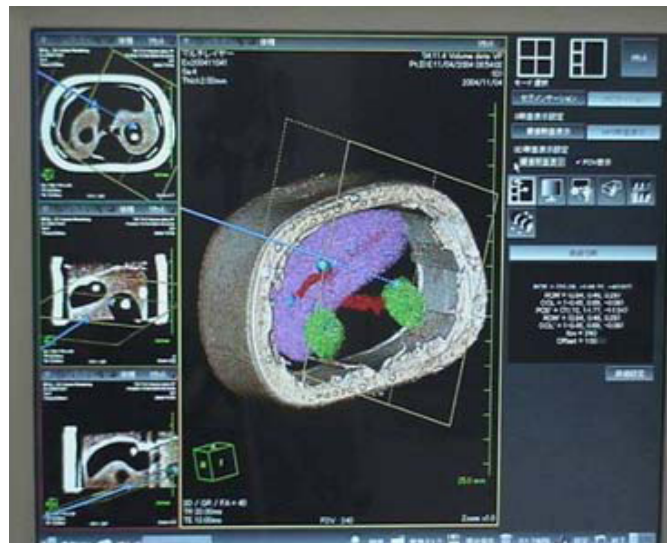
MR images on the master control screen [44].
